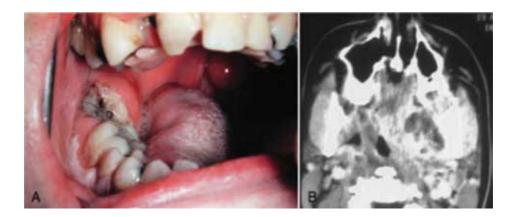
(A) Pterygomandibular space infection. Infected fracture of the mandible involving a partially erupted and carious right lower third molar, which was the source. Significant deviation of the uvula to the opposite side and the swelling of the right anterior tonsillar pillar. (B) CT of a pterygomandibular space abscess. Fluid collection seen between the ascending ramus of the mandible and the medially displaced medial pterygoid muscle. (A from Flynn TR, Topazian RG: Infections of the oral cavity. In Waite D, editor: Textbook of practical oral and maxillofacial surgery. Philadelphia, 1987, Lea & Febiger. B from Flynn TR: The swollen face. Severe odontogenic infections. Emerg Med Clin North Am 15:481, 2000.).
